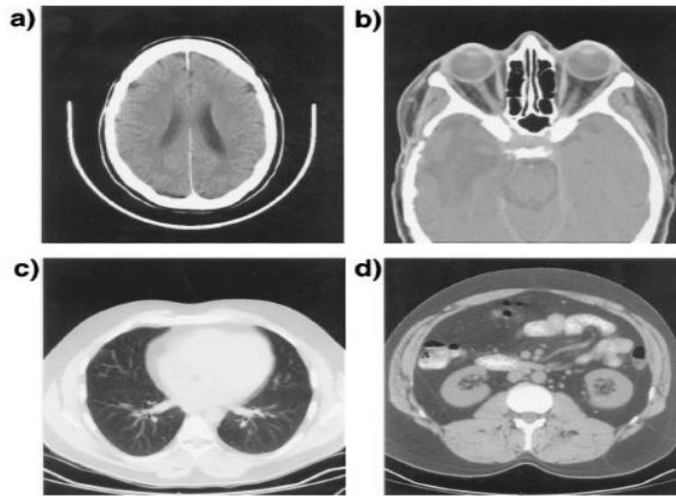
Typical CT images of (a) brain, (b) head showing orbits, (c) chest showing lungs, and (d) abdomen.
